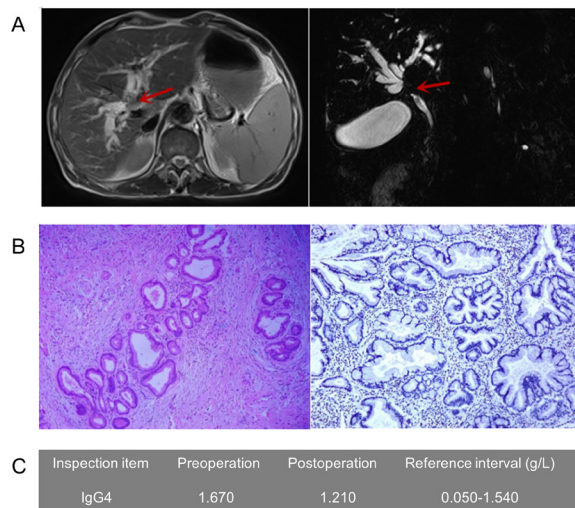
(A), MRI and MRCP showing the confluence of the left and right hepatic ducts and a left bile duct mass; (B), Postoperative pathology showing the dilated bile ducts and negativity for IgG4; (C), Level of IgG4 pre- and post-operatively.
